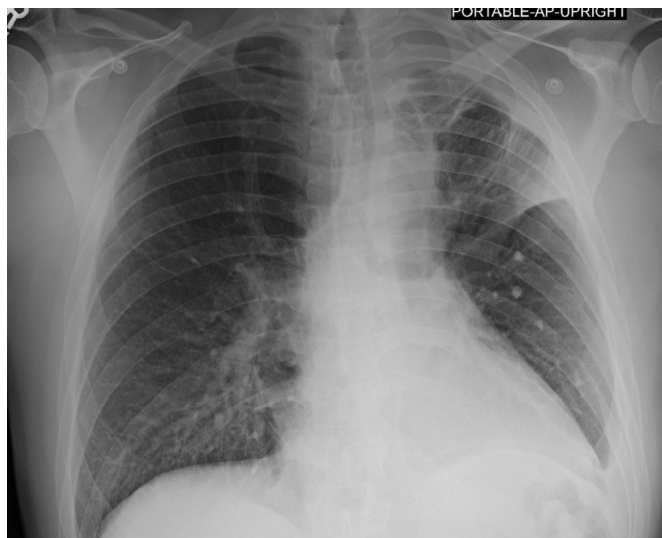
Portable chest X-ray following removal of the endobronchial valves revealed partial expansion of the left upper lobe with areas of streak-like opacities consistent with atelectasis. There was no pneumothorax.
